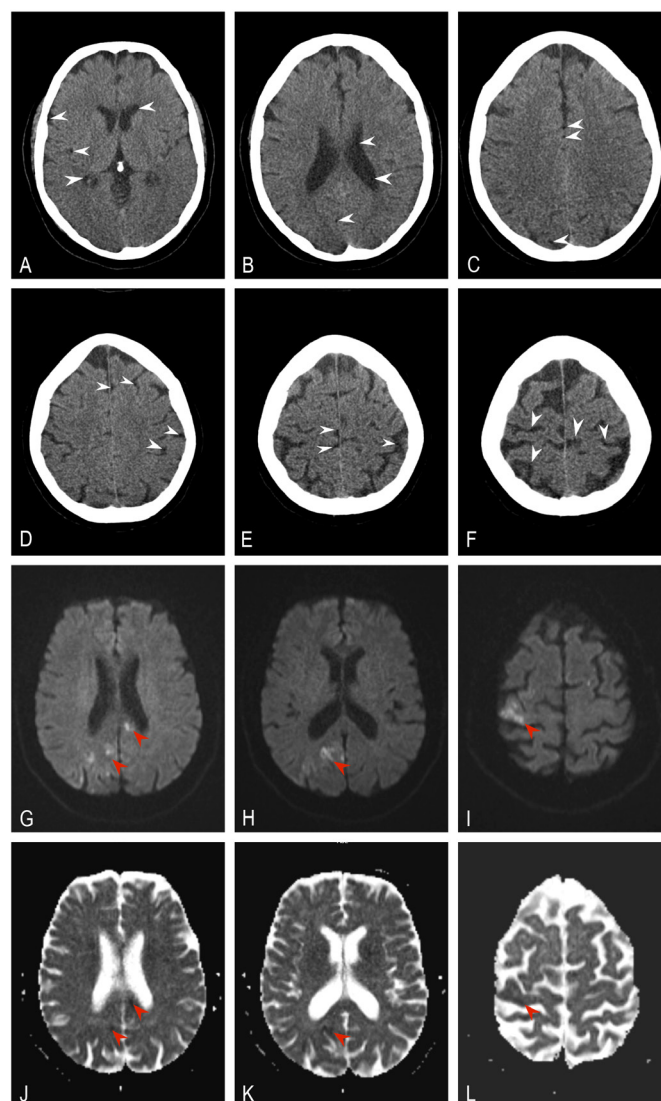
Brain CT scan showing the presence of multiple gas bubbles (white arrowheads), indicative of cerebral gas embolism (A–F). Diffusion-weighted imaging (G–I) and apparent diffusion coefficient (J–L) showing multiple areas of diffusion restriction in both cerebral hemispheres, suggestive of acute ischaemic stroke of embolic source (scarlet arrowheads).
